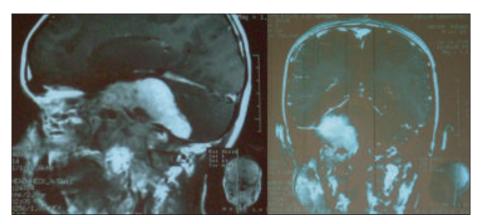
MRI of brain showing the tumour, sagittal and coronal view).
